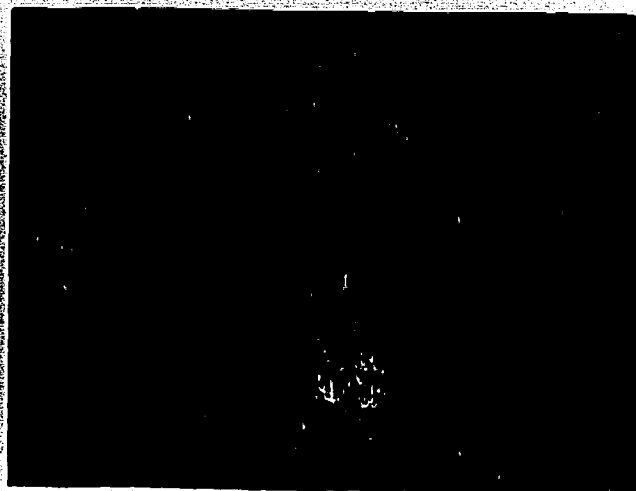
Pseudo-x-ray of "collapsed lung."
